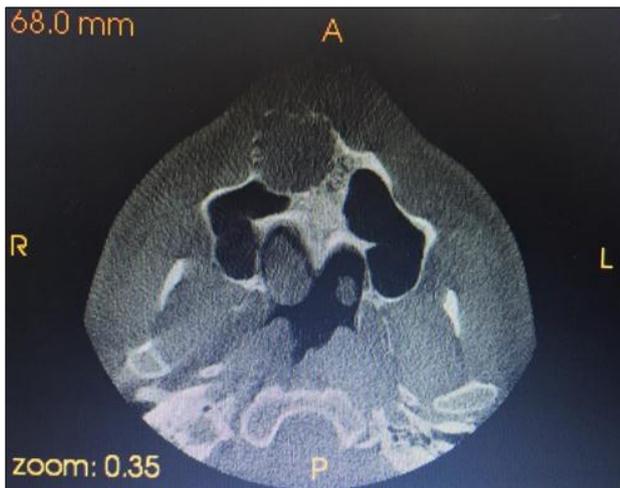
Axial section of Cone Beam CT showing the extent of the lesion
